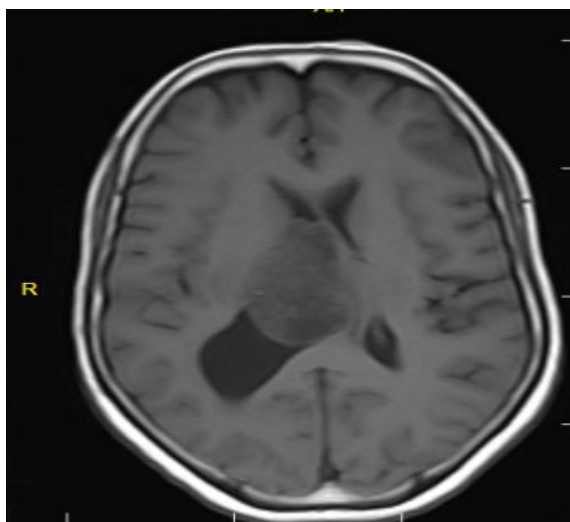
Brain MRI T1 Axial view showing isointense intraventricular mass lesion with mild lateral ventricular compression.
